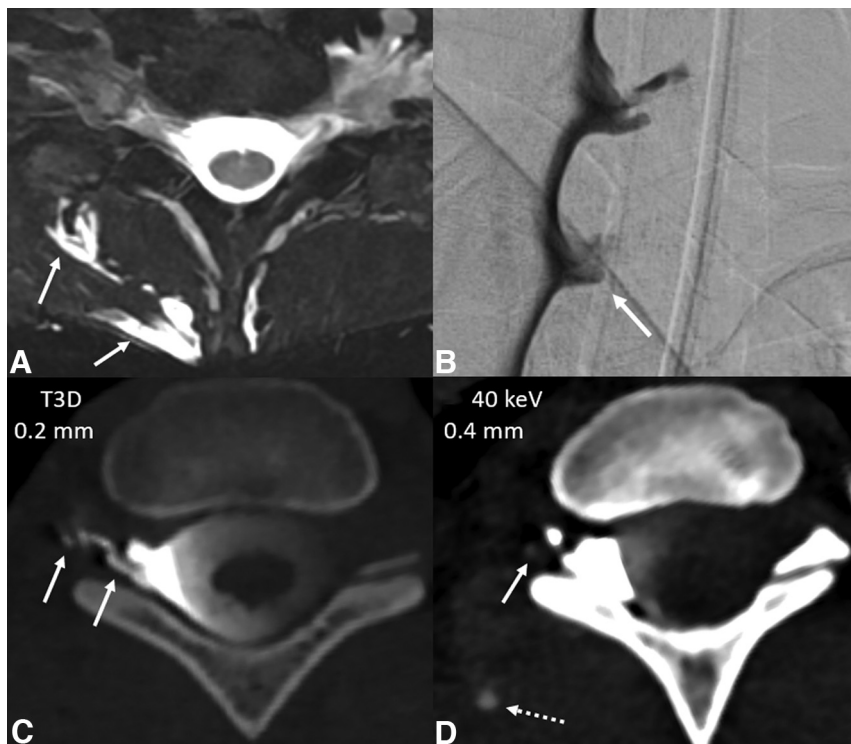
Right T1 CVF associated with a paraspinous venous malformation, demonstrating the complementary benefits of high spatial resolution, 40 keV VMIs, and high temporal resolution on PC-CTM. Axial T2-weighted MR imaging demonstrates a T2 hyperintense venous malformation (A, solid arrows), which extended from C7–T2. Right lateral decubitus DSM shows a small right T1 meningeal diverticulum (B, solid arrow), but no evidence of adjacent venous opacification. Right lateral decubitus PC-CTM was performed next. Axial 0.2 mm T3D (C) from this PC-CTM demonstrates a right T1 CVF (C, solid arrows). A 0.4 mm 40 keV (D) image obtained 8 seconds later shows that the vein has washed away (D, solid arrow), with new subtle opacification of the venous malformation (D, dashed arrow). 40 keV images are especially helpful for detecting subtle areas of contrast opacification such as this.
